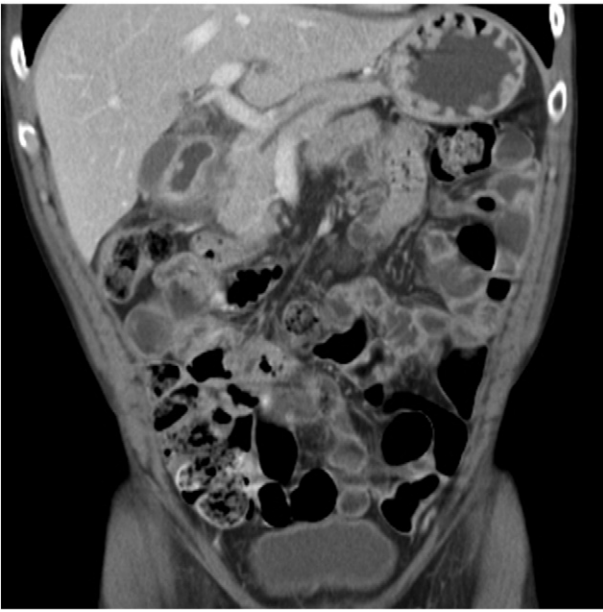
Coronal contrast-enhanced CT demonstrates typical groove pancreatitis (GP) with a sheet-like mass in the groove and adjacent duodenal thickening. This is an example of the “pure form” with the abnormalities largely confined to the pancreaticoduodenal groove.
